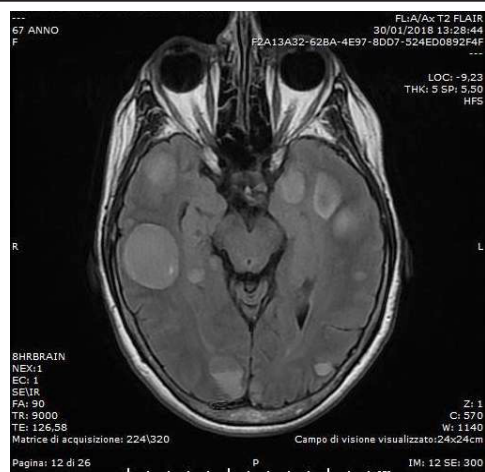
Multiple cystic lesions in axial T2-weighted FLAIR MRI.
